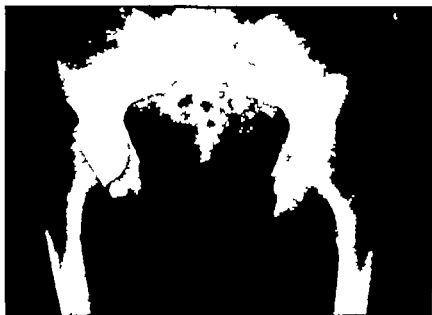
The radiograph of cup arthroplasty of the right hip five years after operation. The patient has good range of movement and is free from pain. Changes are to be observed in the left hip also.
